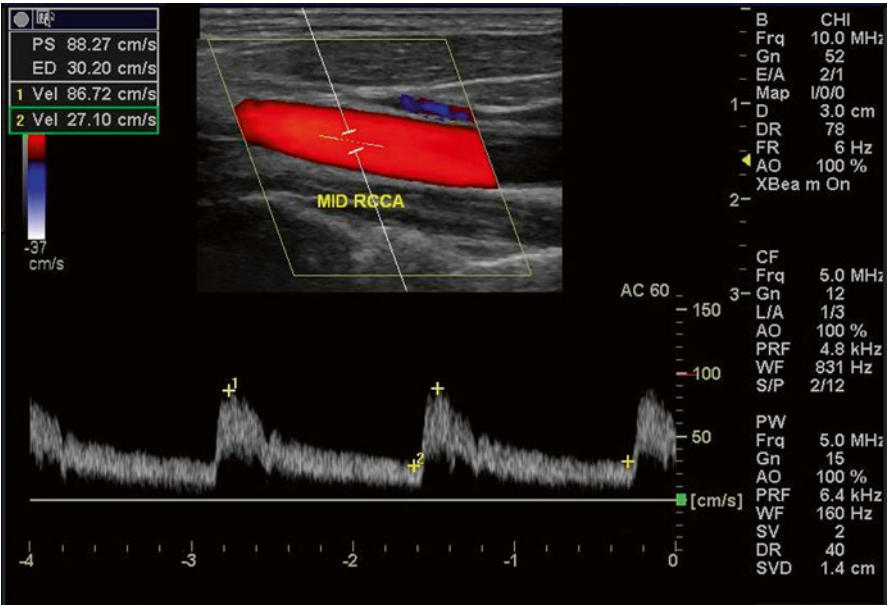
Showing the monitor display during spectral Doppler mode
